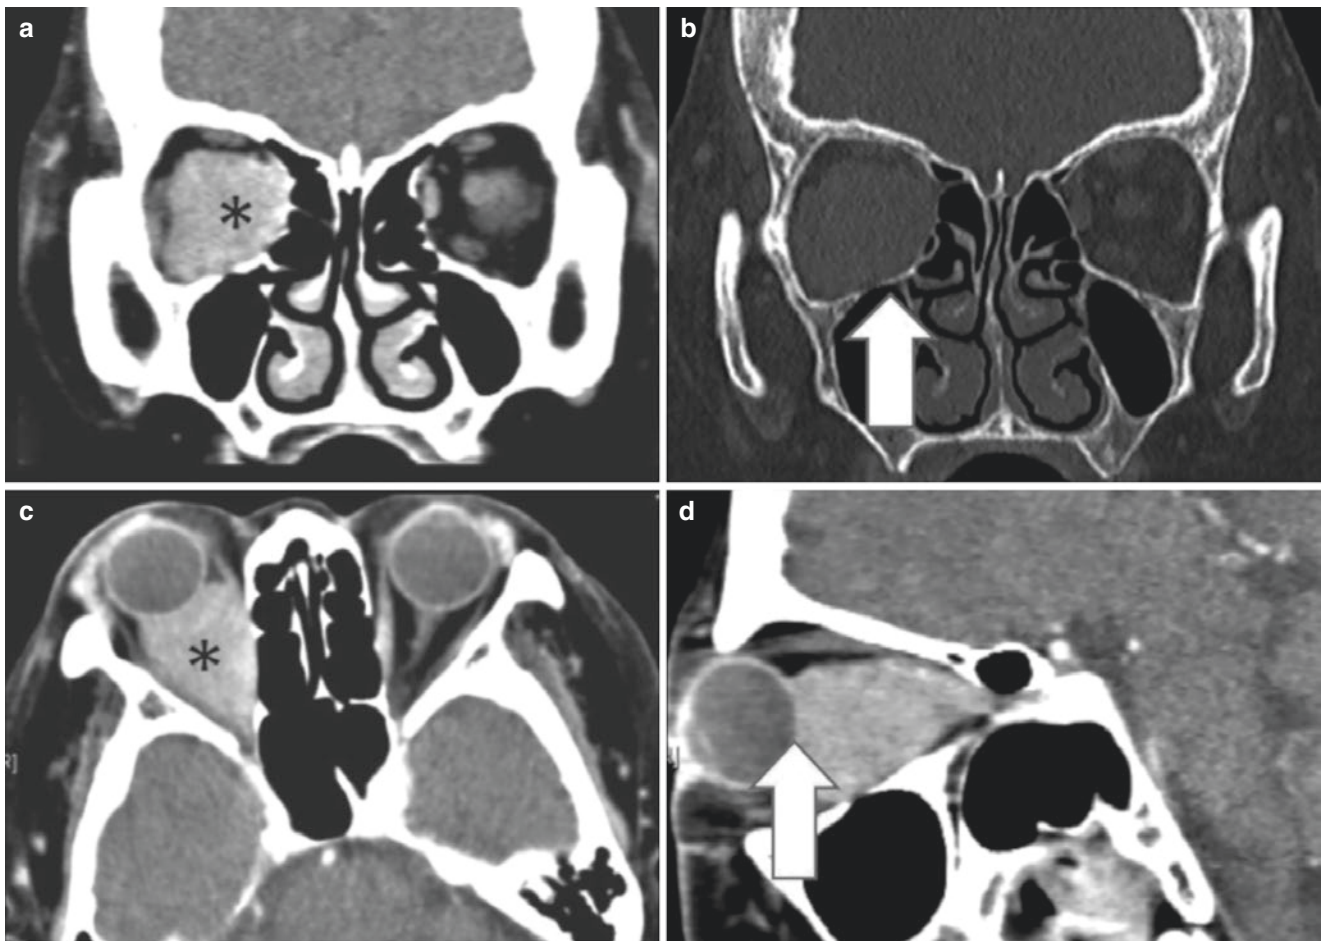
CT scans of case 3: (a) and (b) Coronal scans with contrast and bone window showing an enhancing intraconal tumour (*), and remodelling of the medial wall of the orbit (arrow). (c) Axial CT scan
